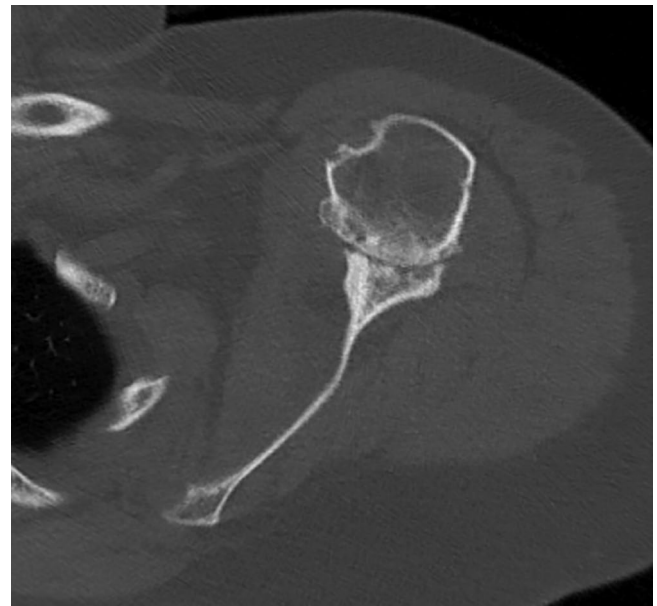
Type D glenoid on axial CT, which, while rare, is characterized by glenoid anteversion.
